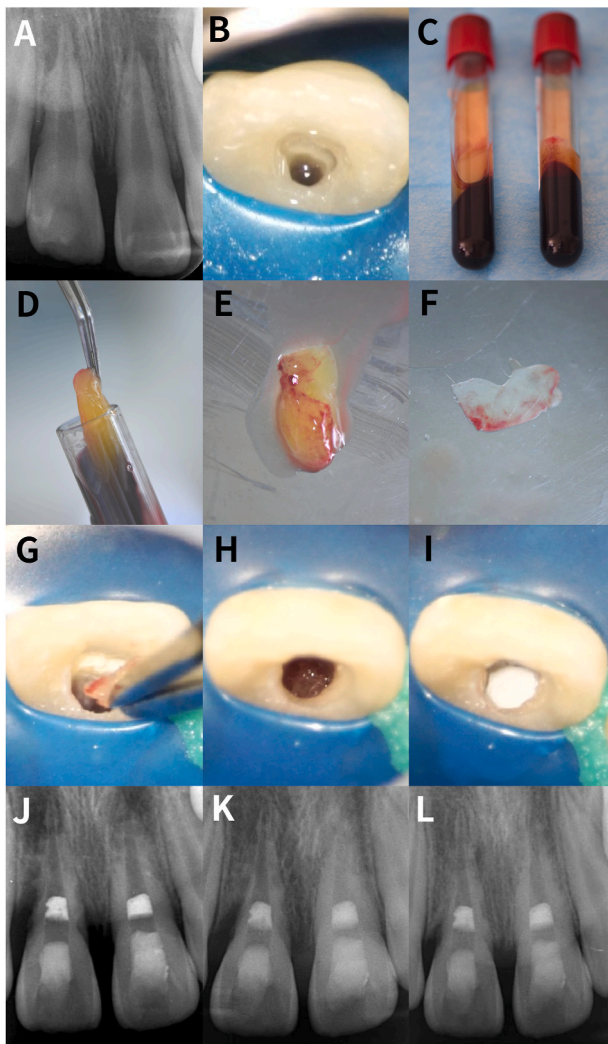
Regenerative endodontic procedures performed with platelet-rich plasma on teeth 8 and 9 of a 9-year-old boy. Both teeth were diagnosed as pulpal necrosis with asymptomatic apical periodontitis. (A) Periapical radiograph obtained at the first visit showed teeth 8 and 9 had external root resorption and periapical lesions. Tooth 8 had an angular bony defect at the distal aspect. The REPs were scheduled one week later for teeth 8 and 9. (B) At the second visit, teeth 8 and 9 were accessed, copiously irrigated and medicated with calcium hydroxide paste for two weeks. At the third visit, platelet-rich plasma was used as an alternative to creating a blood clot for tooth 8 because there was not sufficient blood induced into the canal space by physical irritation of the periapical tissues. Conventional REPs were applied for tooth 9. (C) Venous blood was drawn from the patient and centrifuged to obtain platelet-rich plasma. (D) The platelet-rich plasma was removed from the test tube with sterile pliers. (E) Platelet-rich plasma. (F) A membrane consisting of platelet-rich plasma was prepared by compression using a sterile glass plate. (G) The platelet-rich plasma membrane was cut into fragments. The fragments were placed incrementally into the canal. (H) The platelet-rich plasma membrane fragments were placed to a level that was 3 mm below the cemento-enamel junction (I) A 3-mm thick layer of bioceramic paste was placed over the platelet-rich plasma fragments. (J) Periapical radiograph after REPs. (K) Three-month follow-up radiograph showed complete resolution of the periapical lesion in tooth 9. The distal angular bony defect and periapical lesion of tooth 8 were partially repaired. (L) Six-month follow-up radiograph showed continued healing of the distal angular bony defect and periapical lesion of tooth 8.
